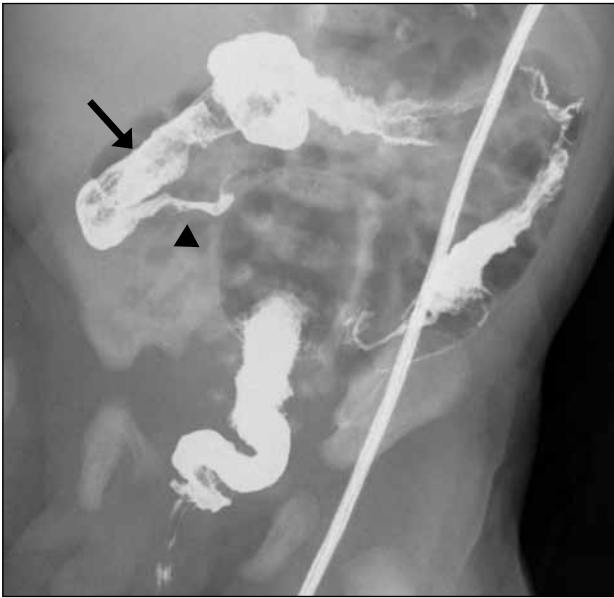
A delayed 24-hour abdominal X-ray shows residual contrast in the ascending colon (arrow) and terminal ileum (arrowhead), suggestive of delayed evacuation.
